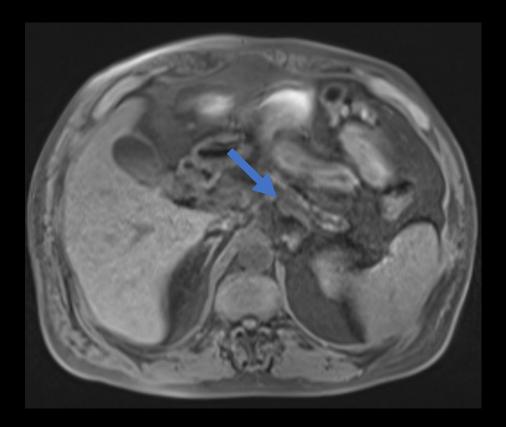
MRI. T1-weighted images with contrast IV (portal phase). Marked pancreatic atrophy with dilatation of the Wirsung duct, that presents irregular shape (arrow). These imaging features suggests chronic pancreatic involvement.
